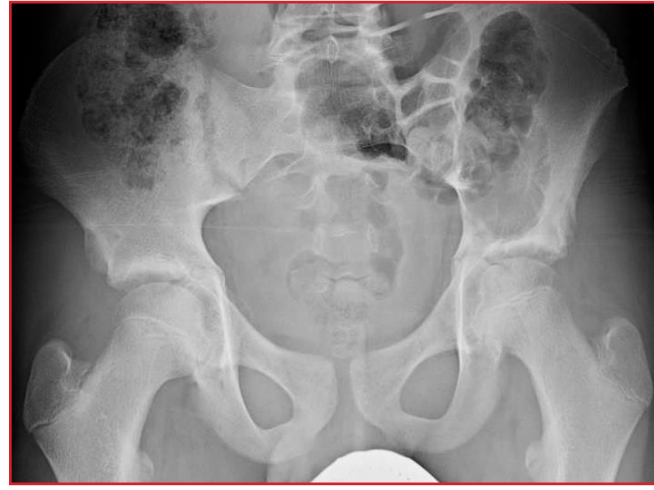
Radiograph of the pelvis obtained before the first procedure shows an expansile, large lytic lesion in the left ilium.
